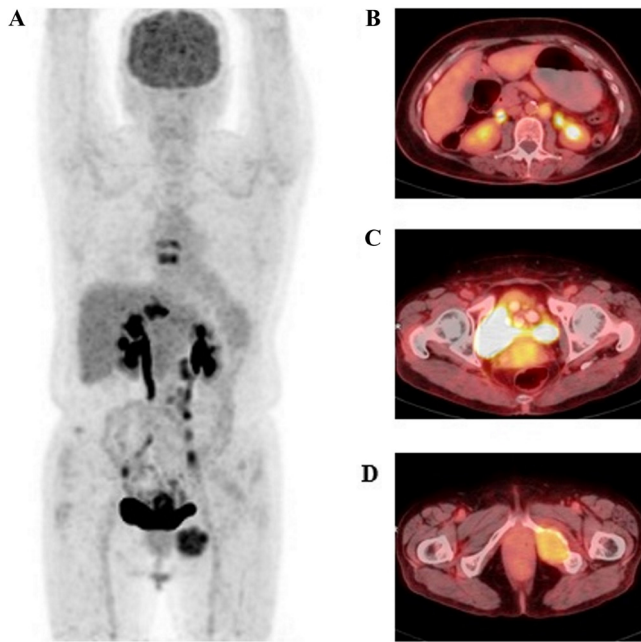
$^{18}\text{F}$ -FDG-PET/CT before treatment (January 2016). (A) PET scan depicting multiple bone lesions, metastases in paraaortic lymph nodes and metastatic node on the uterus stump. Co-registered PET/CT scan demonstrating increased FDG uptake in (B) paraaortic lymph node, (C) node on the vagina stump and (D) left ischium with soft-tissue mass.  $^{18}\text{F}$ -FDG, 2-deoxy-2-[fluorine-18]fluoro-D-glucose; PET, positron emission tomography; CT, computed tomography.
